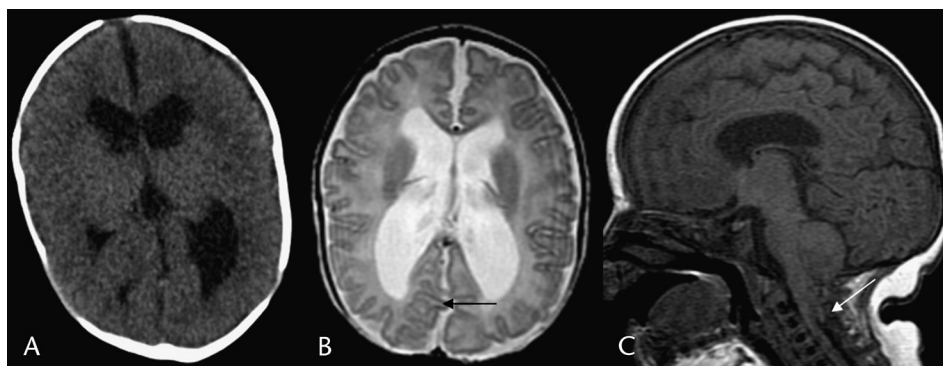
Chiari II in a 12-day-old boy. Axial CT (A) shows dysmorphic and enlarged lateral ventricles (a large foramen magnum with no fourth ventricle was also observed along with other characteristic findings—see text). Sagittal T1 (B) and axial T2 (C) images show a small posterior fossa, low tentorium, and herniation of the cerebellar vermis into the cervical canal posterior to a low cervicomedullary junction (white arrow). The fourth ventricle is elongated and small. Tectal beaking is present along with occipital polygyria/stenogyria (black arrow). Moderate to marked third and lateral ventriculomegaly is present with disproportionate enlargement of the posterior horns.
